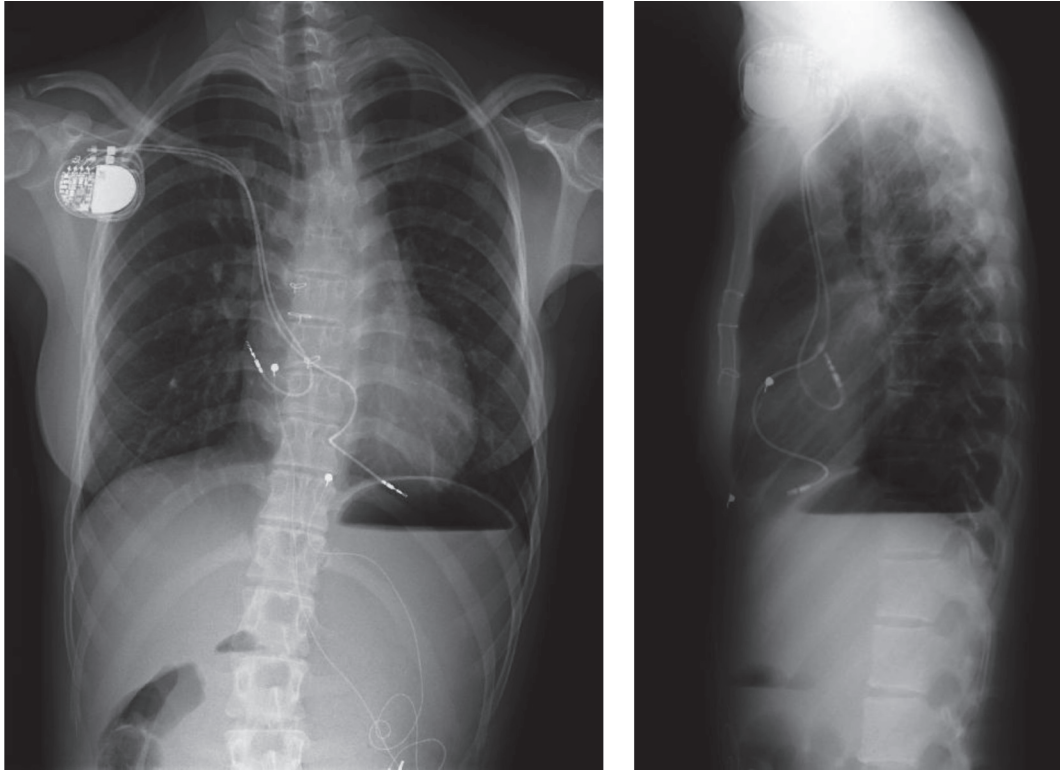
Chest X-ray taken 7 years after transvenous pacemaker implantation when she was 17 years old (2013.6.20). The lengths of both leads are long enough for fit with her grown up body.
